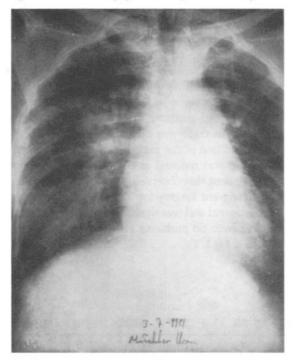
Chest X-ray showing diffuse infiltration.
